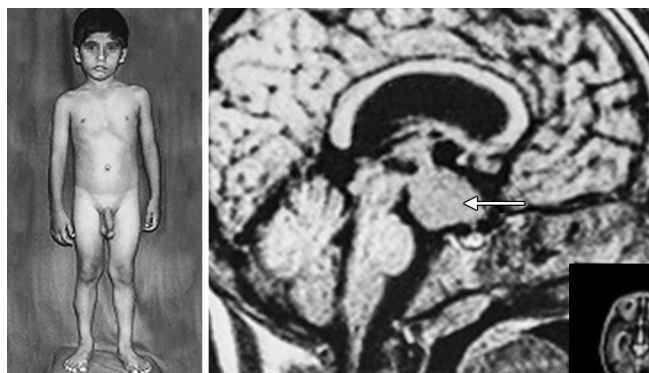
A 3-year-old boy with CPP due to a hypothalamic hamartoma. Note enlargement of the external genitalia, especially the testes along with the generally muscular physical appearance. The white arrow indicates the hypothalamic hamartoma in the MRI of brain
